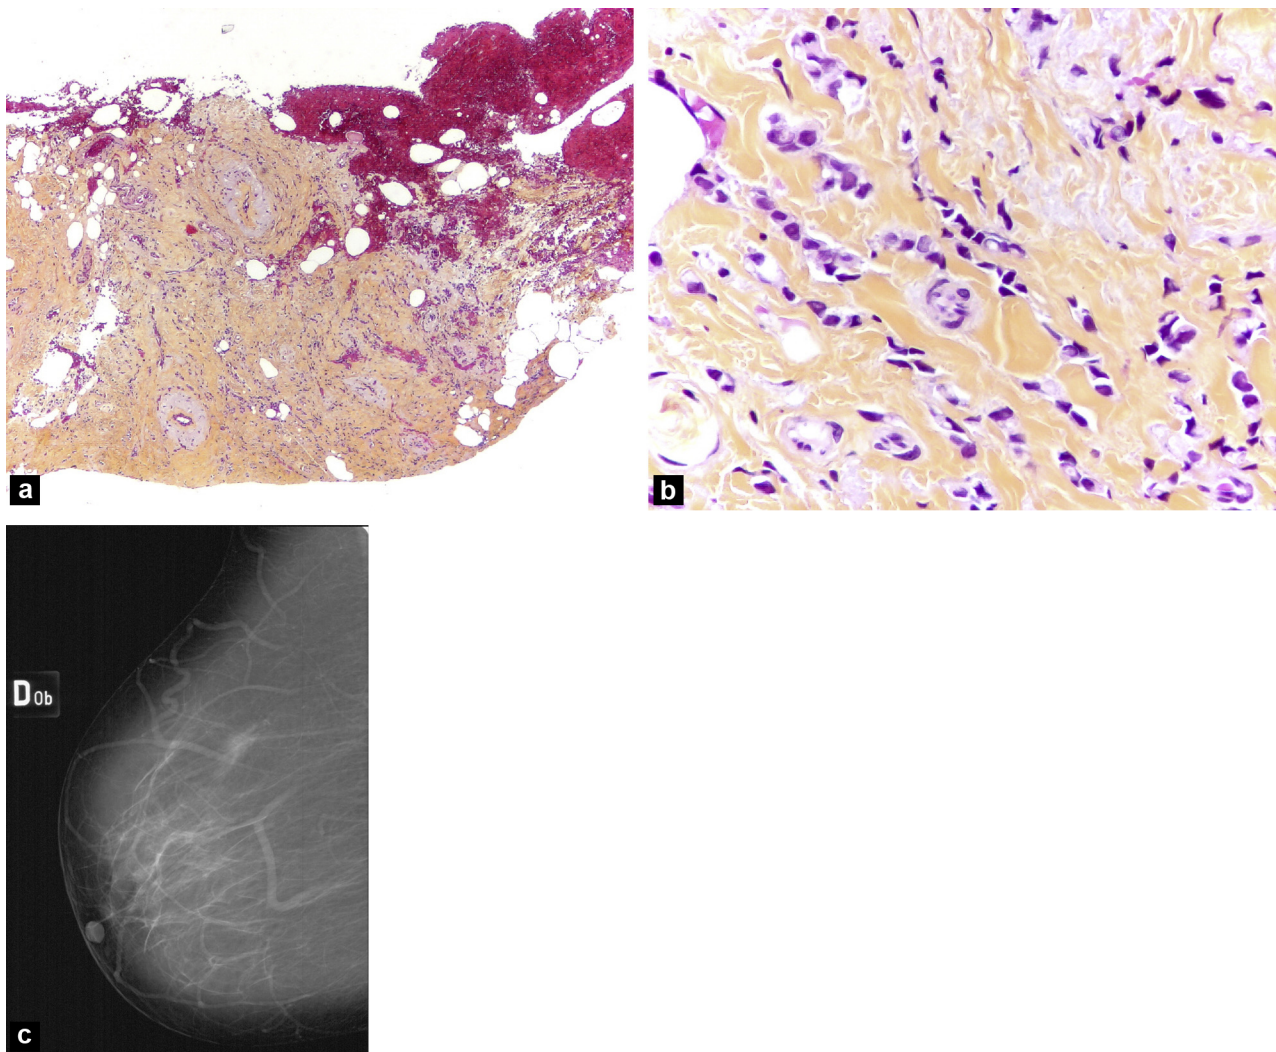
Infiltrating lobular carcinoma. a: microbiopsy under sonography: infiltration of the fat tissue by isolated cells without fibrous stroma reaction; b: HES $\times 160$. Arrangement of cells in "Indian file"; c: mammogram, right oblique image: focal hyperdensity at the union of the upper quadrants, recently appeared.
